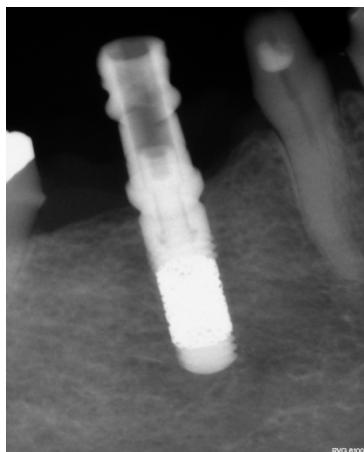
TM Dental Implant placed in the mandible (right first molar); periapical radiograph at baseline.
